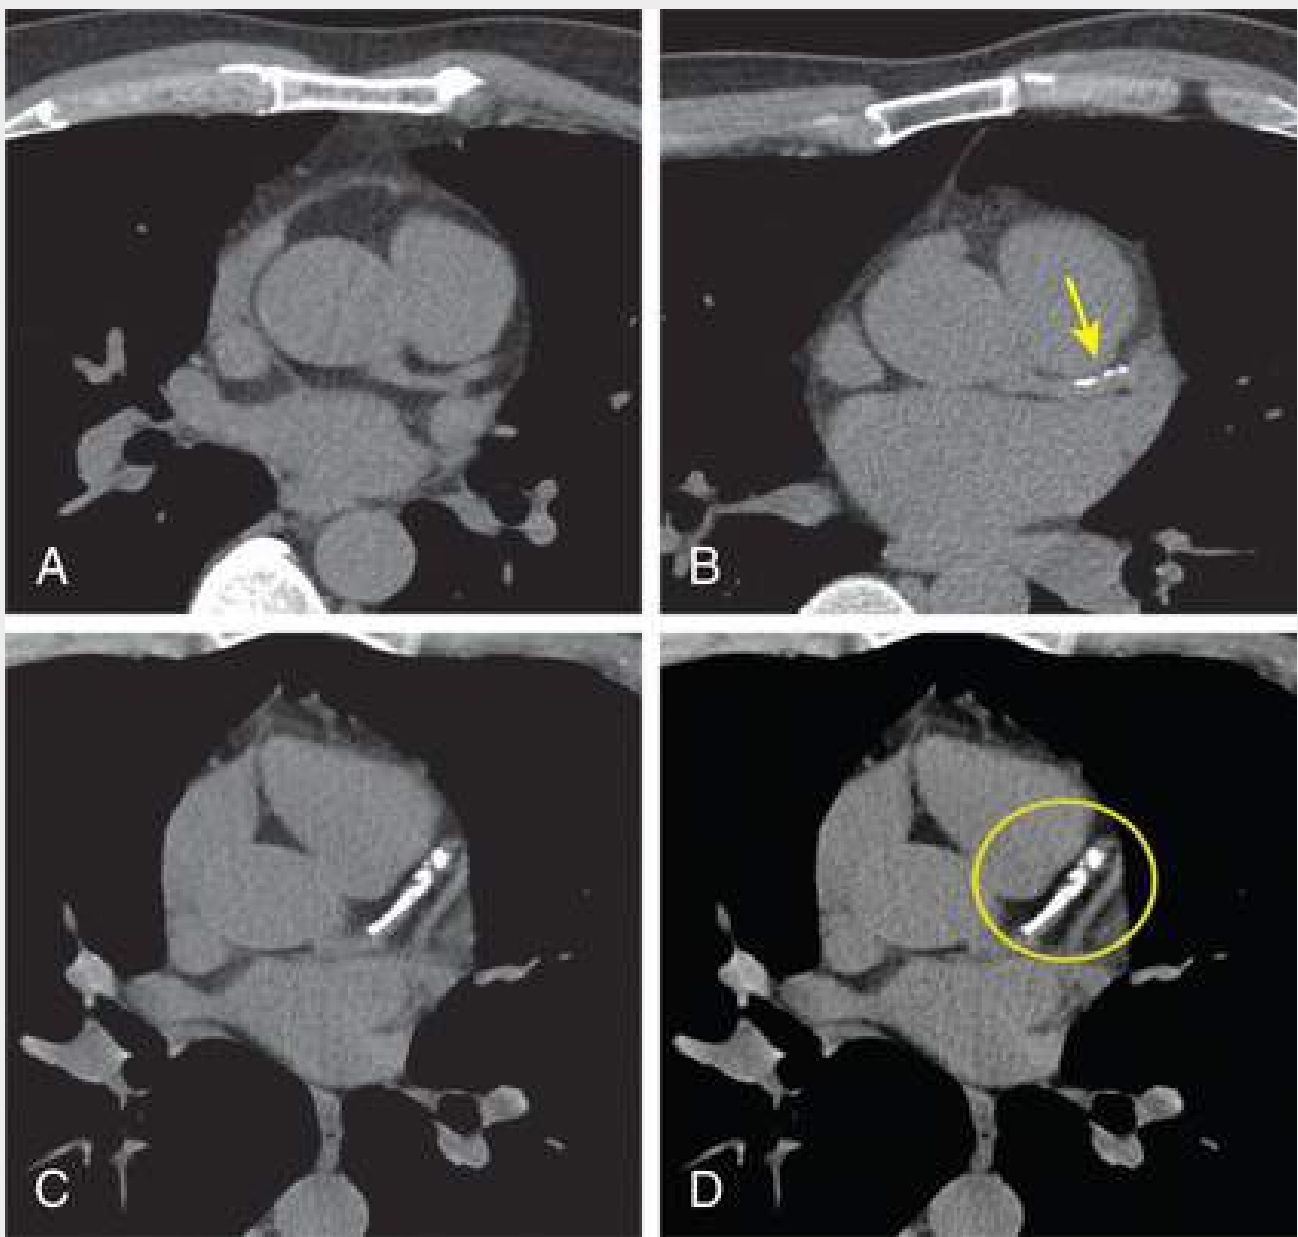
Examples of coronary artery calcium (CAC) imaging. Representative axial slices of a CAC CT scan demonstrate A, no evident calcium; B, mild coronary calcium; and C, severe coronary calcium. D, Method of quantification of the Agatston CAC score, in which the surface area of the coronary calcium is multiplied by the Hounsfield unit (HU) density conversion factor: a value of 1 = 139 to 199 HU, 2 = 200 to 299 HU, 3 = 300 to 399 HUs, and 4 = >400 HU.
